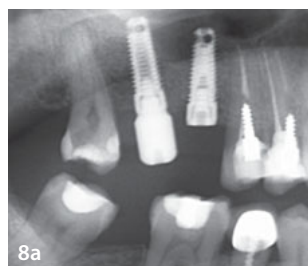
Panoramic radiograph immediately following implantation and sinus elevation of two DIVA implants at the maxillary right first and second molars.
